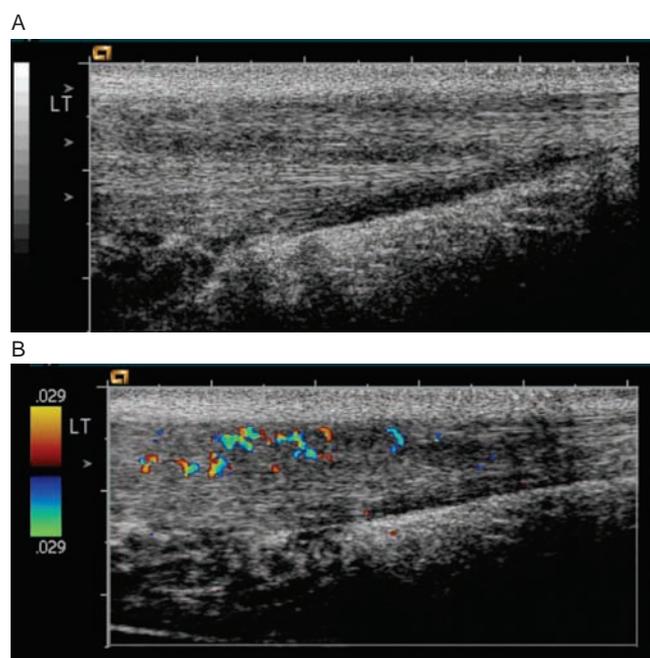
(A) Grey-scale ultrasound showing a slightly thickened Achilles mid-portion with structural changes (irregular fibre bundle structure and hypoechoicity) in the dorsal tendon and irregular dorsal tendon line (superficial-skin side tendon line). (B) Doppler examination showing high blood flow, mainly in a longitudinal pattern, in the region with structural changes in the dorsal tendon.
